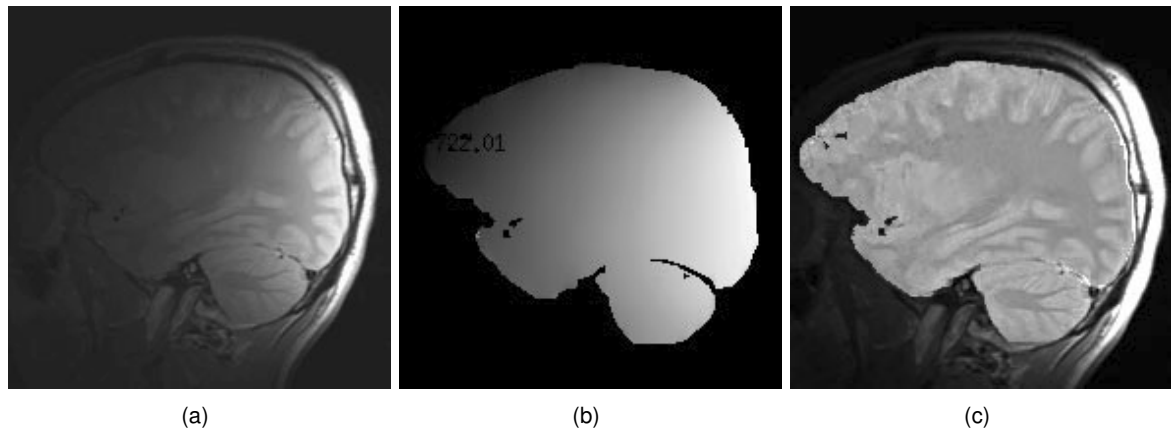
MRI image with bias field (a), computed bias field (b) and image corrected at the brain region (c) (Courtesy of W. Wells).
